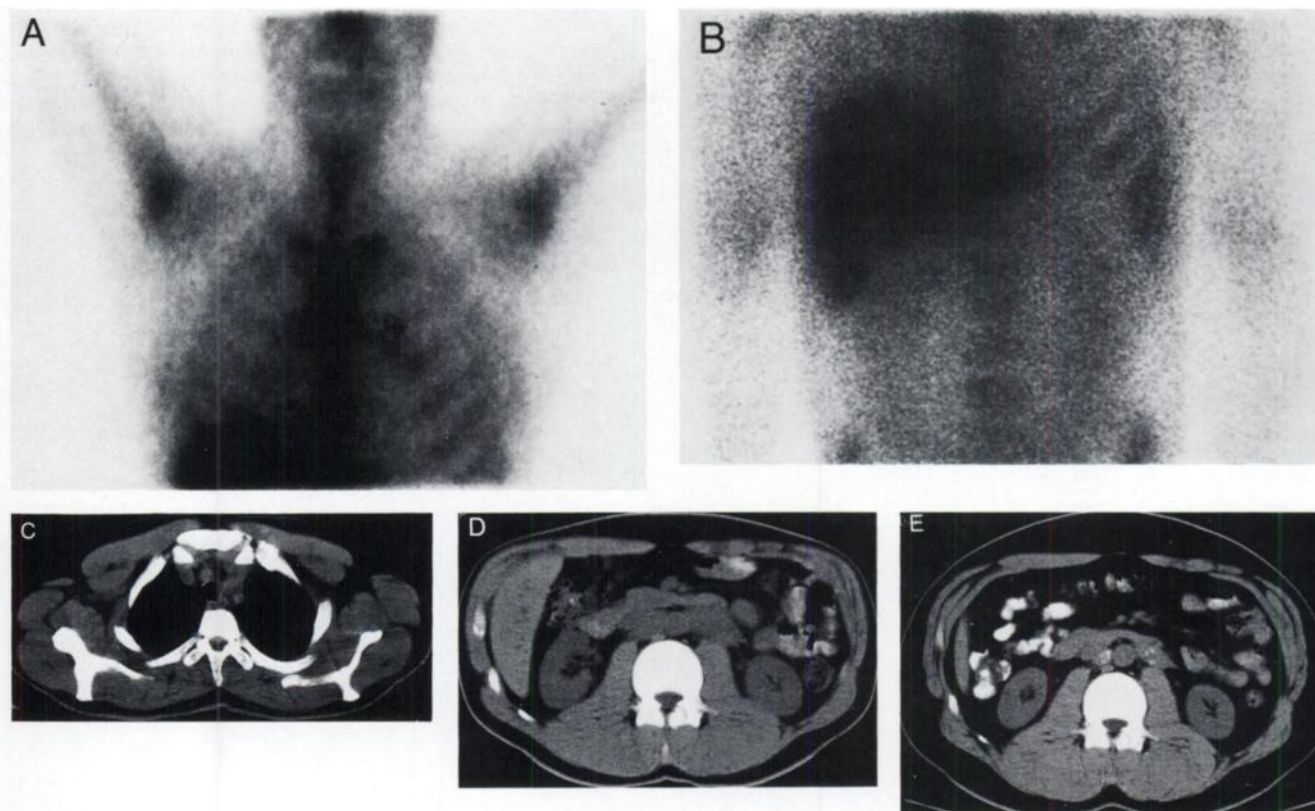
Gallium-67 and CT scans 24 days following completion of chemotherapy. (A, B) There is no evidence of residual gallium avid tumor. Faint bilateral uptake was considered response to treatment. (C) CT scan demonstrates improvement of left supraclavicular and mediastinal mass. There was no evidence of abnormal density area in bilateral region. (D) CT scan shows decreased in size of retroperitoneal masses with calcification. These masses extended from the level of the renal hila to approximately the level of bifurcation. (E) CT scan 377 days following completion of therapy. The confluent soft tissue with stippled calcification remained in para-aortic region.
